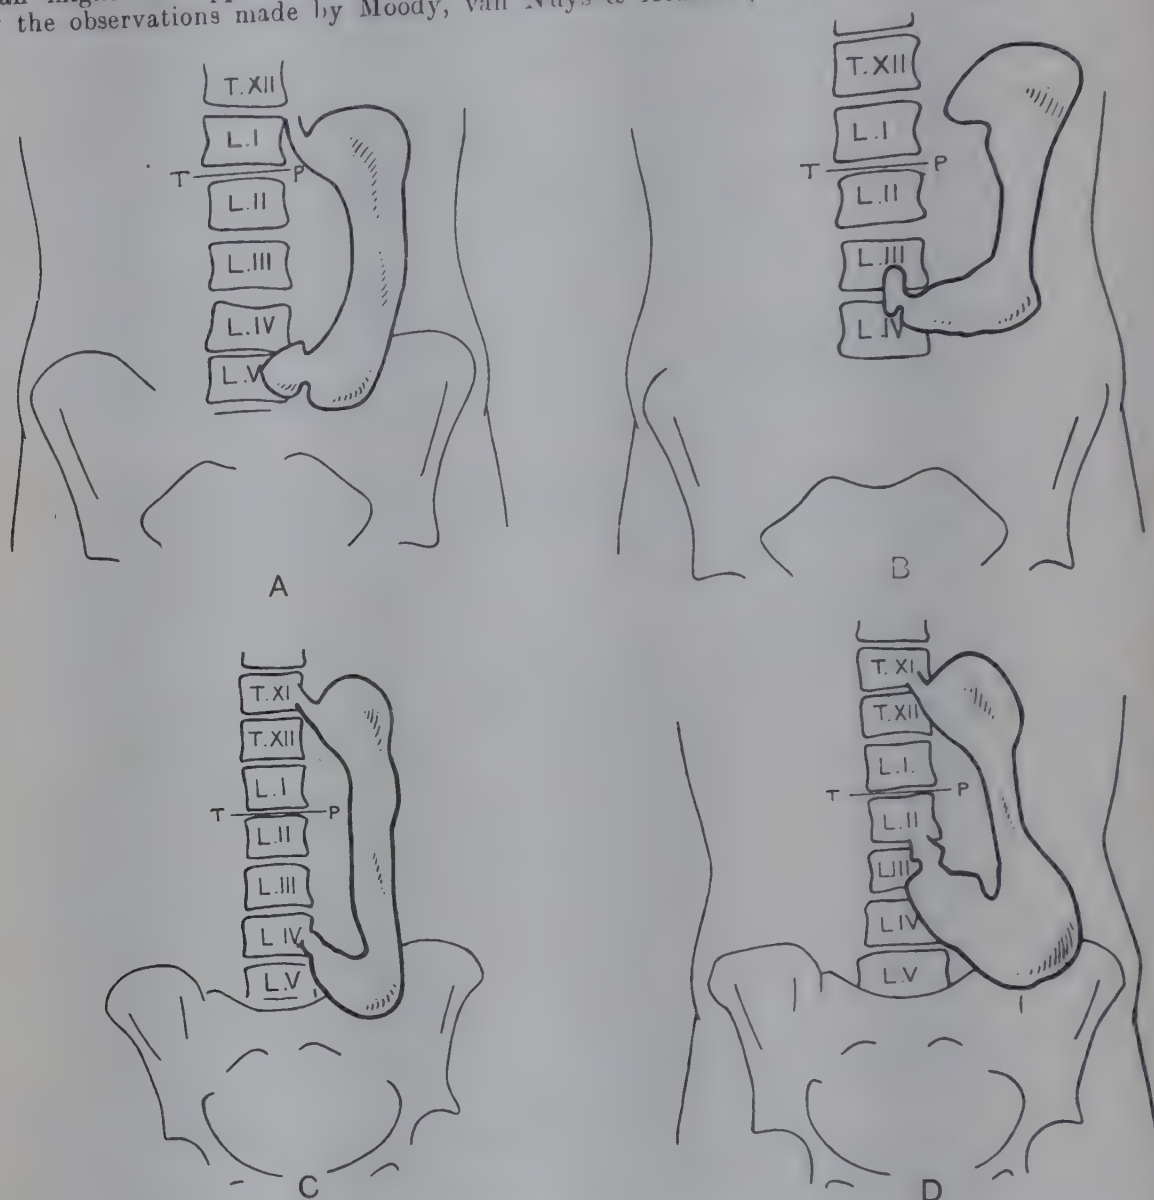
TRACINGS OF OUTLINES OF STOMACH AS DEFINED BY X-RAY EXAMINATION. (After Moody, Van Nuys, & Kidder, 1929.) A. Empty stomach, subject erect, the form of the stomach a 'reverse L', with short horizontal arm; lowest part of the greater curvature 5 cm. below the plane of the iliac crests opposite the upper half of the first sacral vertebra. B. Same stomach, subject prone. C. Empty stomach, subject erect, pylorus opposite the fourth lumbar vertebra. D. Same stomach, subject prone, pylorus opposite the third lumbar vertebra. (From the *Anatomical Record*, by permission of the Wistar Institute.)
